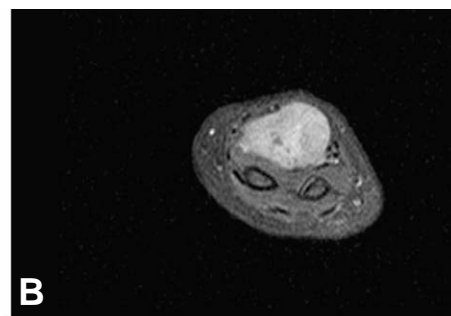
MRI revealed that T-2 weighted sagittal (A) and T2-weighted axial (B) image showed a solid, well-demarcated mass with a relatively high signal intensity compared to the muscle tissue, but without calcification.
